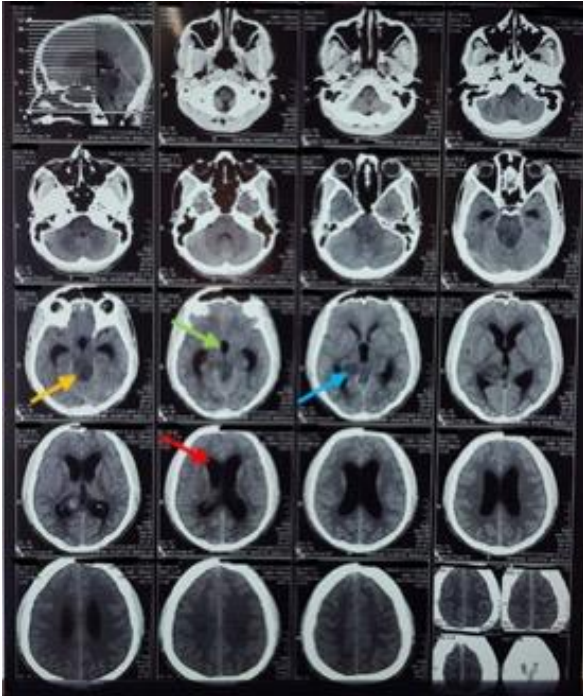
CT showing the lesion (Yellow arrow) in tectal plate infiltrating the thalamus (Blue Arrow) and Obstructive Hydrocephalus with enlarged 3rd (Green arrow) and lateral ventricles. (Red arrow)
